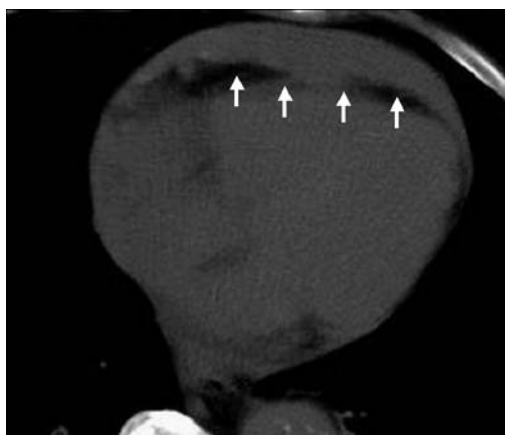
Unenhanced CT images are important to identify complications of aortic dissection, such as pericardial effusion (arrows, axial scan), that can be slightly hyperdense, indicating the presence of hemopericardium.
